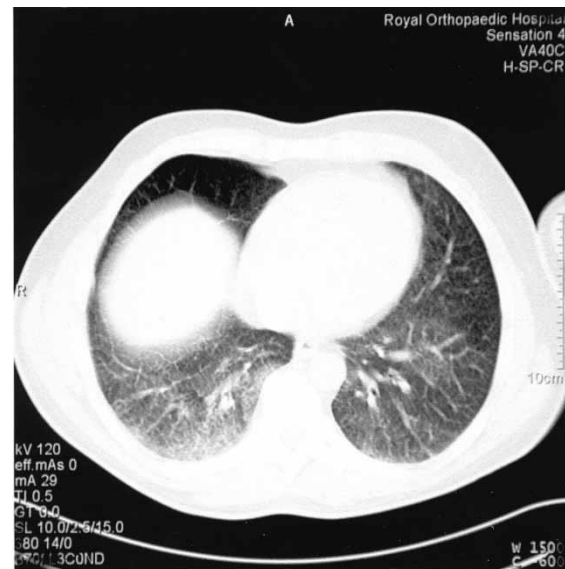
Computed tomography of the chest. This shows lung window images of lung bases showing reticulo-nodular pattern. These ill-defined changes are suggestive of interstitial lung disease though miliary metastases are difficult to rule out.
